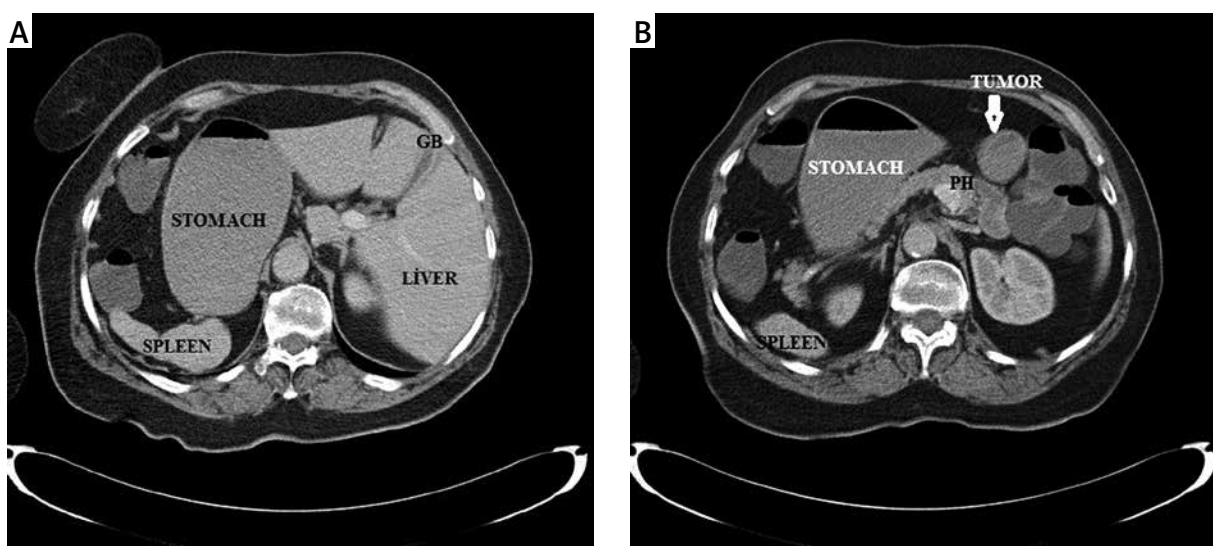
A – Abdominal computed tomography revealed a complete right-left reversal of the abdominal organs, B – thickened wall of gastric antrum without distant metastasis
